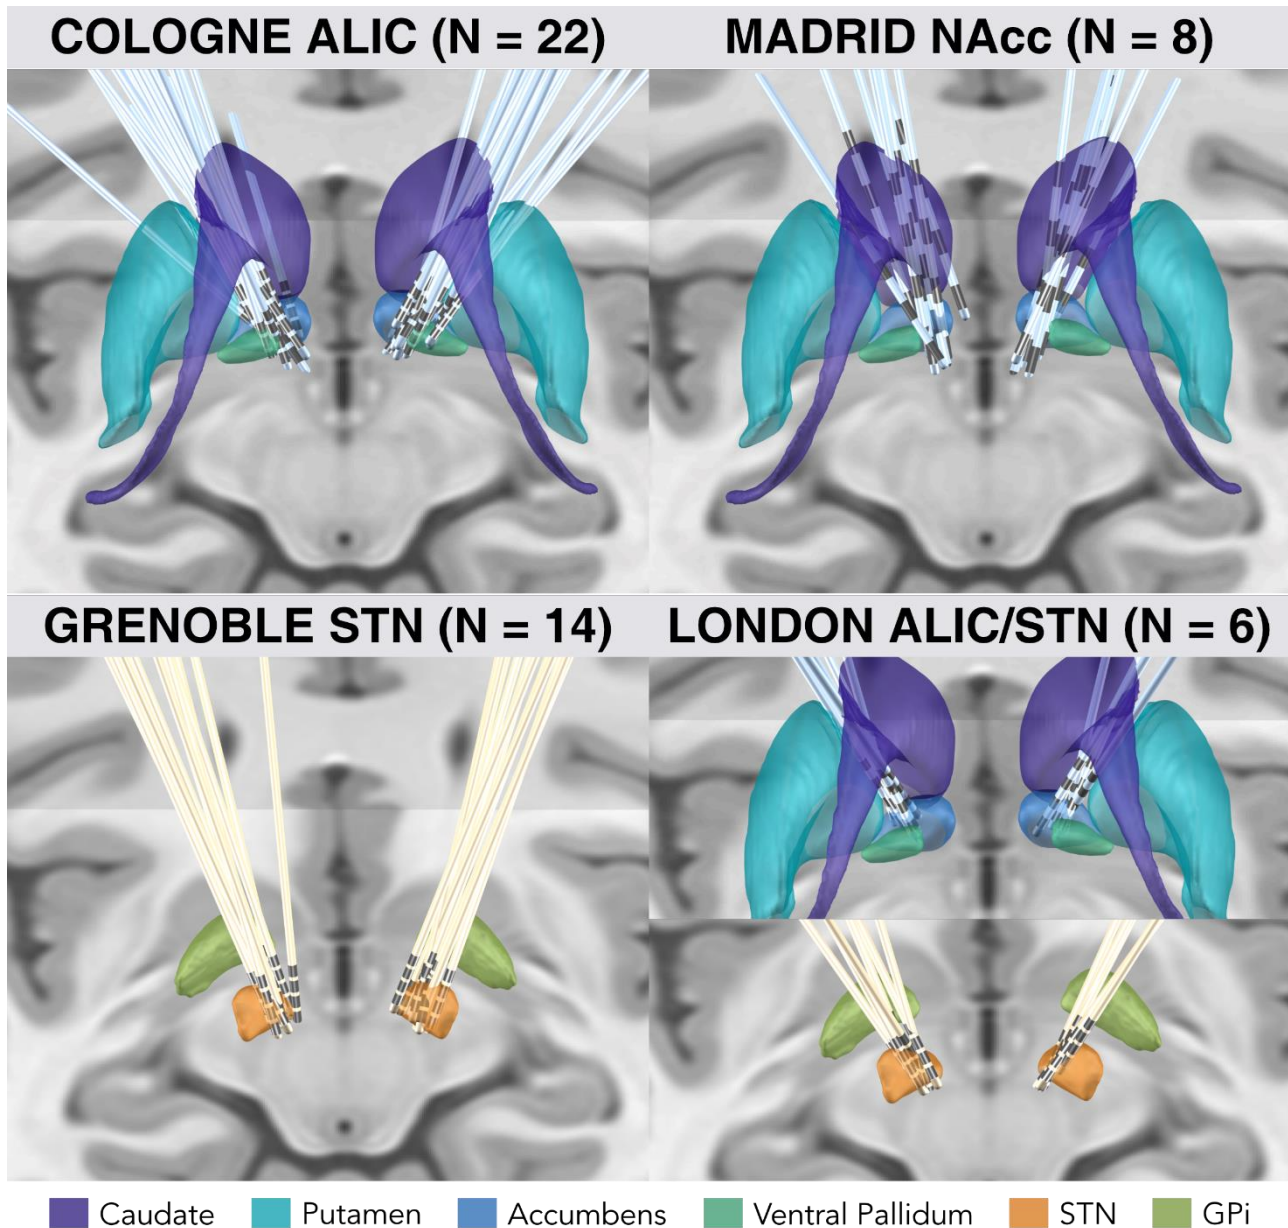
Overview of lead electrodes placement of the two training/cross-validation cohorts (left) targeting ALIC DBS (Cologne) and STN DBS (Grenoble) cohorts, and the two test cohorts (right) targeting NAcc (Madrid) and both ALIC & STN with four electrodes per patient (London). Subcortical structures defined by CIT168 Reinforcement Learning Atlas⁴⁰ (ALIC/NAcc region) and DISTAL Atlas⁴¹ (STN region), with coronal and axial planes of the T1-weighted ICMB 152 2009b nonlinear template⁴² as background.
